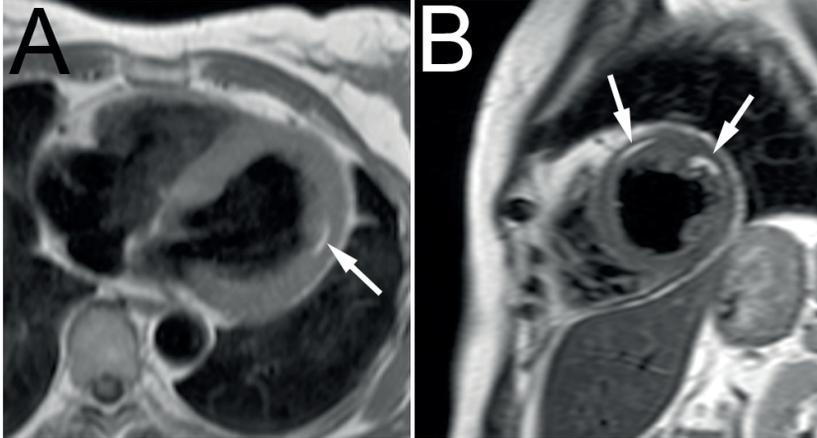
Fatty foci in the myocardium demonstrated on MRI in a 49-year-old female patient with TSC. (A) Transverse dark-blood T1-weighted TSE image. Arrow points at fatty focus in the left ventricular wall. (B) Short axis dark-blood T2-weighted TSE image. Arrows points at fatty foci in the left ventricular wall. TSE indicates Turbo Spin Echo.
